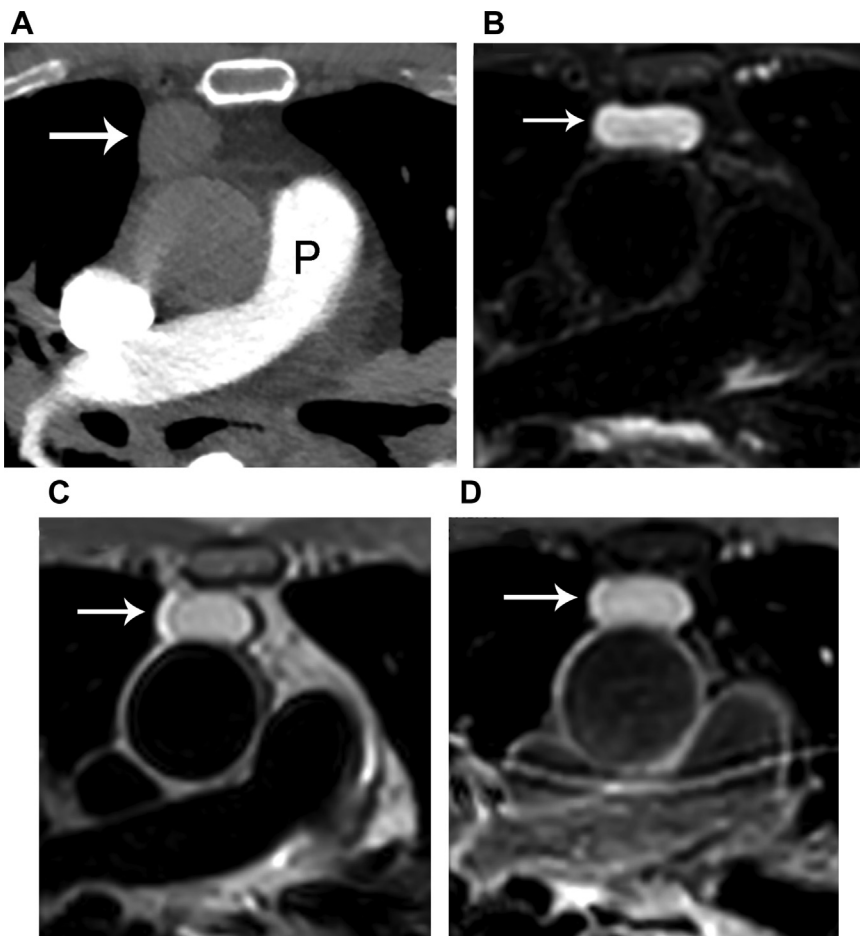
Thymic cyst in a 68-year-old man with shortness of breath. (A) A contrast-enhanced axial CT scan of the chest at the level of the pulmonary trunk (P) demonstrates a homogeneous prevascular mediastinal mass measuring 60 Hounsfield units (*arrow*), suspicious for a solid lesion such as thymoma. (B) An axial T2-weighted MR image demonstrates homogeneous high signal intensity without thick septations or nodules (*arrow*). (C) An axial T1-weighted MR image demonstrates homogeneous high signal intensity in the lesion (*arrow*). (D) An axial T1-weighted MR image obtained after the administration of intravenous gadolinium contrast demonstrates no enhancement, thick septations or nodules, characterizing this lesion as a thymic cyst and differentiating it from a cystic thymoma.
